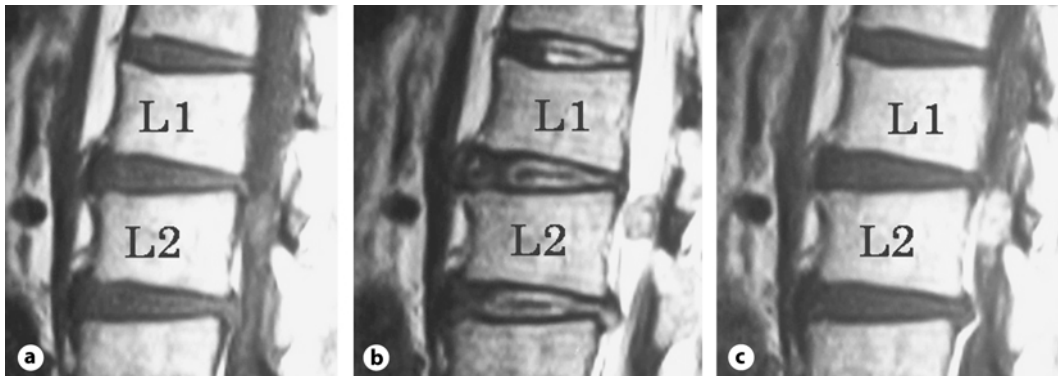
Spinal MRI showed a disc hernia at the L2-L3 level and a generally isointense intradural tumor with focal high-intensity T1-weighted images at the level of L1-L2 (a). On T2-weighted MRI, the tumor demonstrated high intensity with focal low intensity (b). The tumor is homogeneously enhanced by gadolinium (c).
